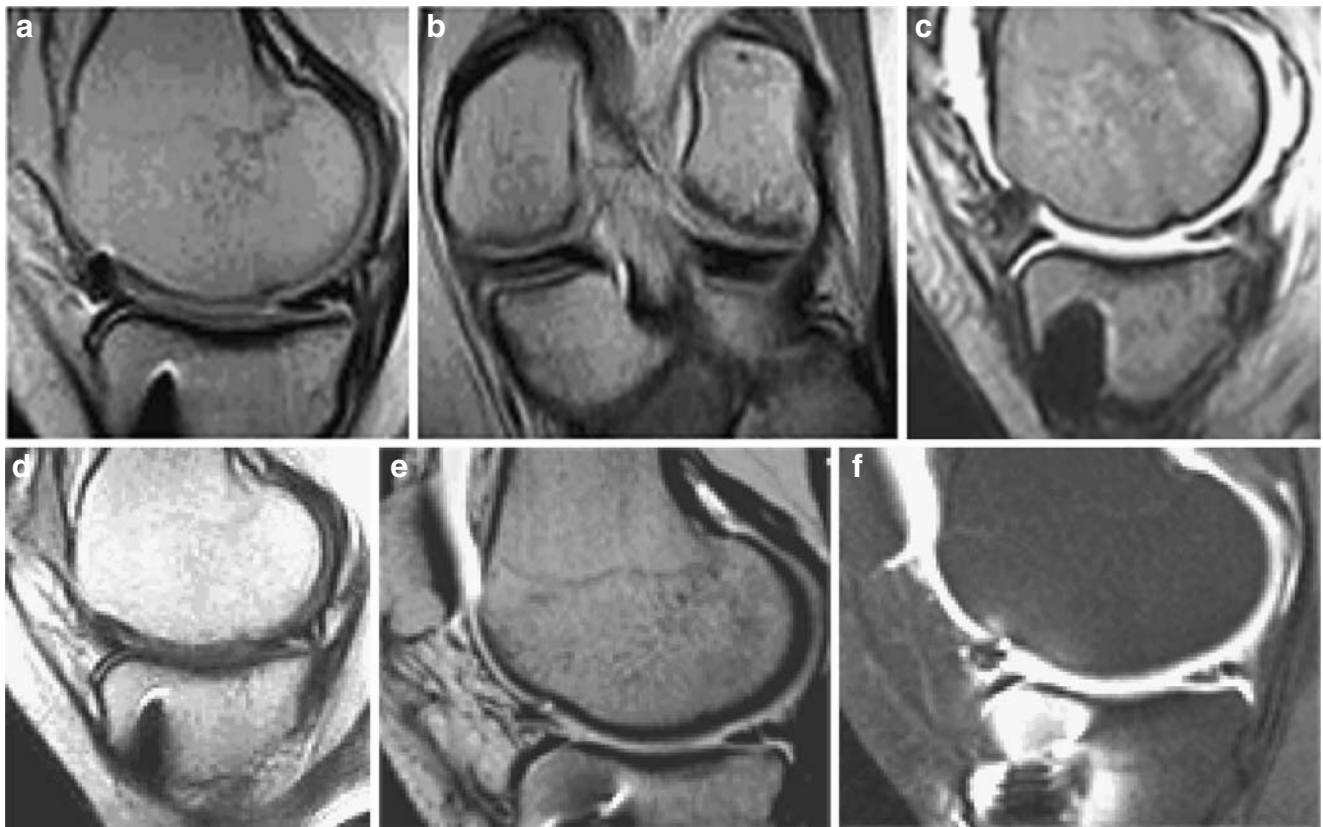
Recurrent meniscal tear of the posterior horn of the medial meniscus after preservation surgery at MR arthrographic imaging 0.2-T magnet: sagittal and coronal T1-weighted SE images (a, b), sagittal T1-weighted 3D GE image (c), sagittal T2-weighted TSE image (d); 1.5-T magnet: sagittal T1-weighted SE image (e), sagittal T1-weighted fat suppressed SE image (f). MRA displays a notching of the medial
